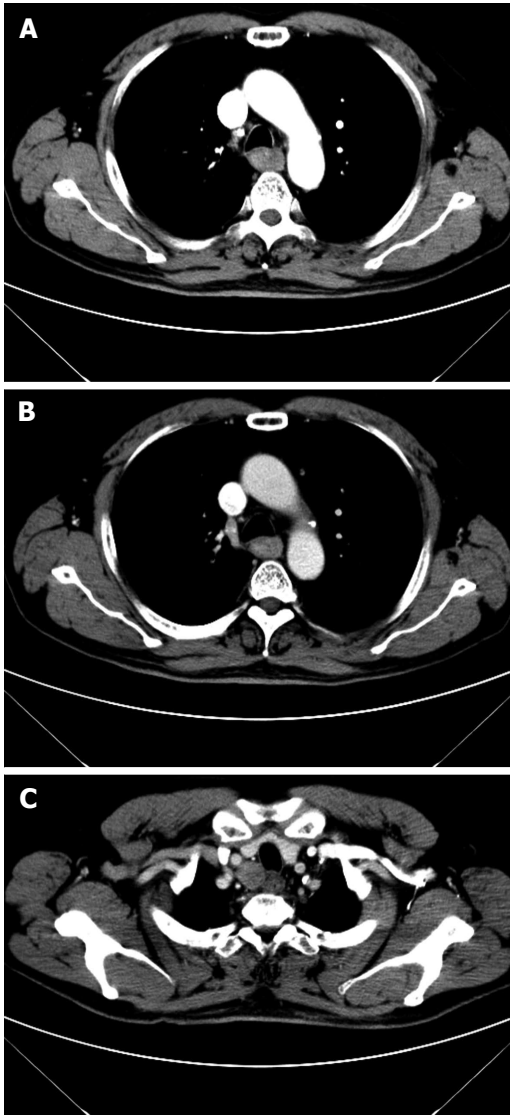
A 61-year-old male with squamous cell carcinoma in the first third section of esophagus. At computed tomography, esophageal cancer shows a soft tissue mass, with irregular luminal narrowing. The located wall thickening was asymmetric. The lesion shows moderate arterial phase enhancement (A) and slight venous phase enhancement (B). The enlarged lymph node metastasis is shown in the upper right paratracheal (C).
